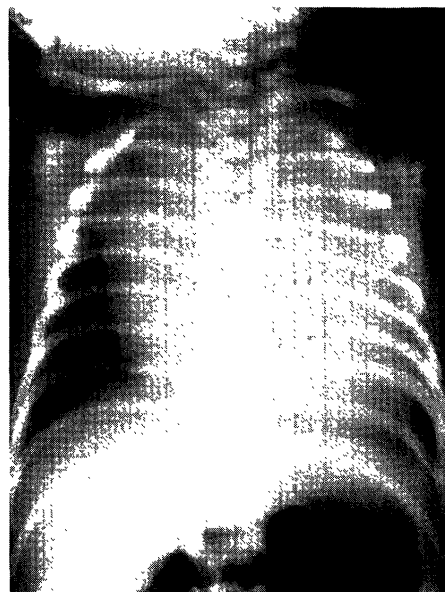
Chest radiograph on admission (day 0) showing the enlarged heart with a cardiothoracic ratio of 79%. The right atrium and the right ventricle are especially enlarged.
